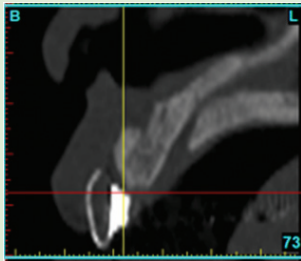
Implant planning. CBCT scan with radiographic guide. Guide shows the contour of the planned crown and the intended access screw hole. Modifications on implant angulation and angled abutments will be used in this case. Also bone graft procedures will be required at the time of implant placement.
